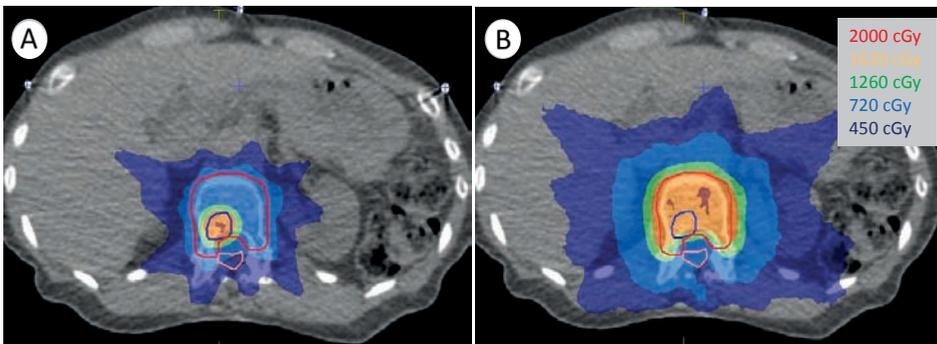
Delineation and planning for representative case 7. (A) Axial planning CT slice showing the simultaneous integrated boost (SIB) SBRT dose distribution for a small metastasis in the L1 lumbar vertebral body. (B) The non-SIB SBRT radiation treatment plan that this patient would have been given without the SIB SBRT approach. In this patient, the dose to the elective surrounding relatively healthy bone was effectively reduced from 18.4 Gy to 10.9 Gy.
